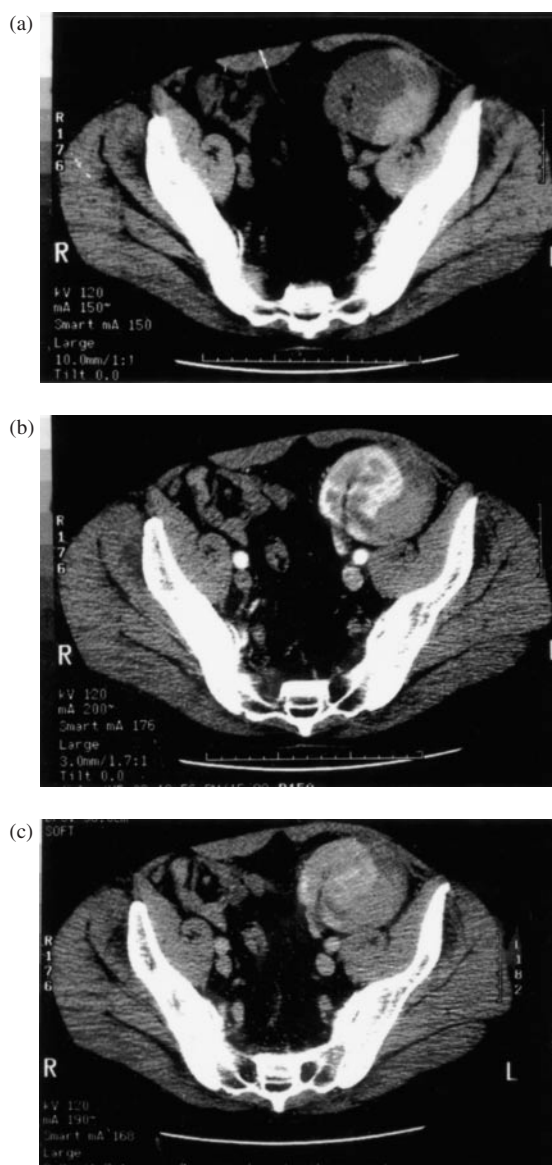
The pre contrast CT image (a) in which the blood has higher attenuation (brighter) compared with the kidney. The second image (b) is post-contrast in the arterial phase. The renal cortex is enhanced and the haematoma appears relatively lower in attenuation (darker) than the renal parenchyma. In the parenchymal phase (c) there is still no contrast in the collecting system and the kidney continues to appear a little brighter.
